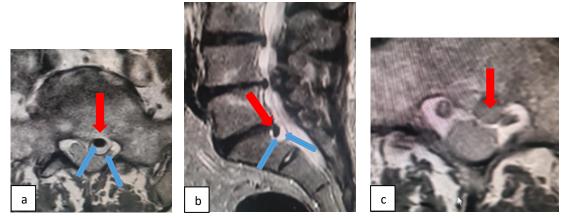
a*): T2 axial scan: Partial vacuolization of the hernia (hypointense signal) (red arrow) with hyperintense "target" peripheral portion with high water content in relation to colliquation phenomena (blue arrows); b): Sagittal T2 STIR MRI: partial vacuolation of the hernia (red arrow), peripheral colliquation (blue arrows); c): More caudal T2 axial MRI scan: the herniated disc presents a disc-like intensity in its most caudal portion (red arrow).
